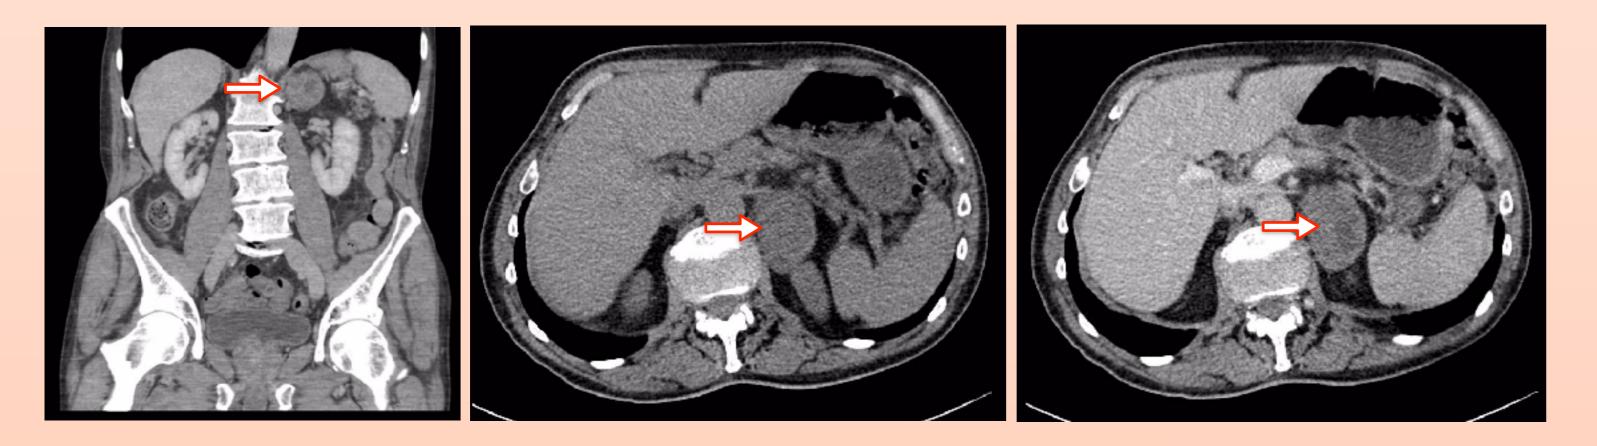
CT adrenals: Left: Coronal image of CT abdomen depicting adrenal 5.5cm x 4.0cm lesion (arrow). Axial views pre-contrast (middle) and 60s post-contrast (right), highlighting features concerning for primary adrenocortical carcinoma with no contrast washout.
